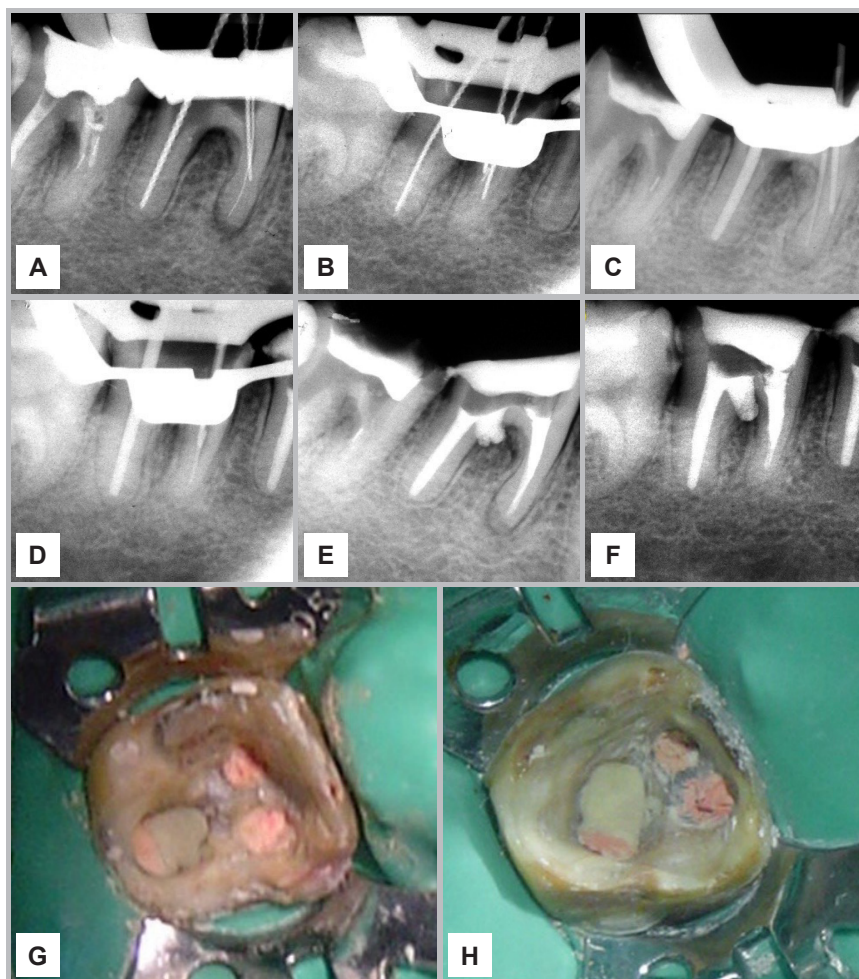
A) Tooth 46: file removal and working length determination. B) Tooth 47: file removal and working length determination. C) Tooth 46: cone fit verification. D) Tooth 47: cone fit verification. E) Tooth 46: post-obturation control radiograph and perforation sealing. F) Tooth 47: post-obturation control radiograph and perforation sealing. G) Tooth 47: photograph of the pulp chamber floor after perforation sealing and canal obturation. H) Tooth 46: photograph of the pulp chamber floor after perforation sealing and canal obturation.
